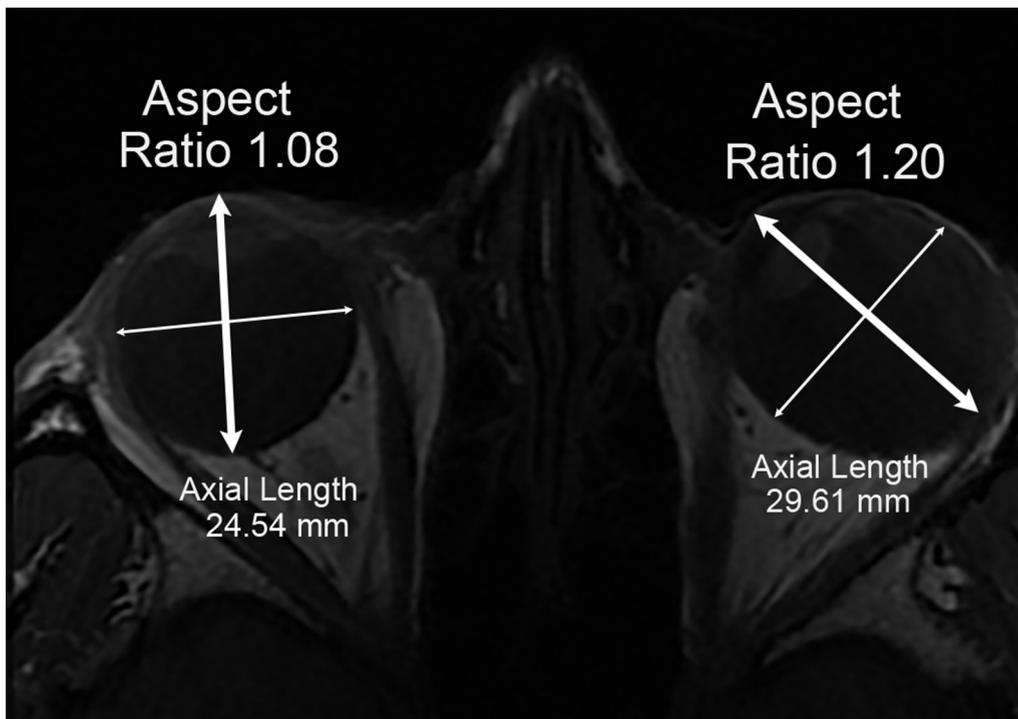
Axial magnetic resonance image of esotropic subject with left unilateral axial myopia. Major axes of ellipses fitting each globe cross section are indicated by bold bidirectional arrows and minor axes by thin arrows. Emmetropic right eye cross section is nearly circular, even including the cornea for aspect ratio 1.08, while cross section of diffusely staphylomatous, myopic left eye is oval with aspect ratio 1.20. Axial length of the myopic left eye is about 5 mm greater than emmetropic right eye.
